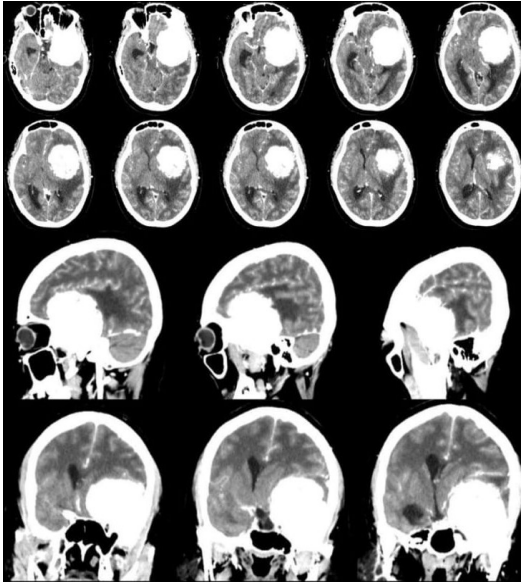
Contrast-Enhanced Head CT scan
